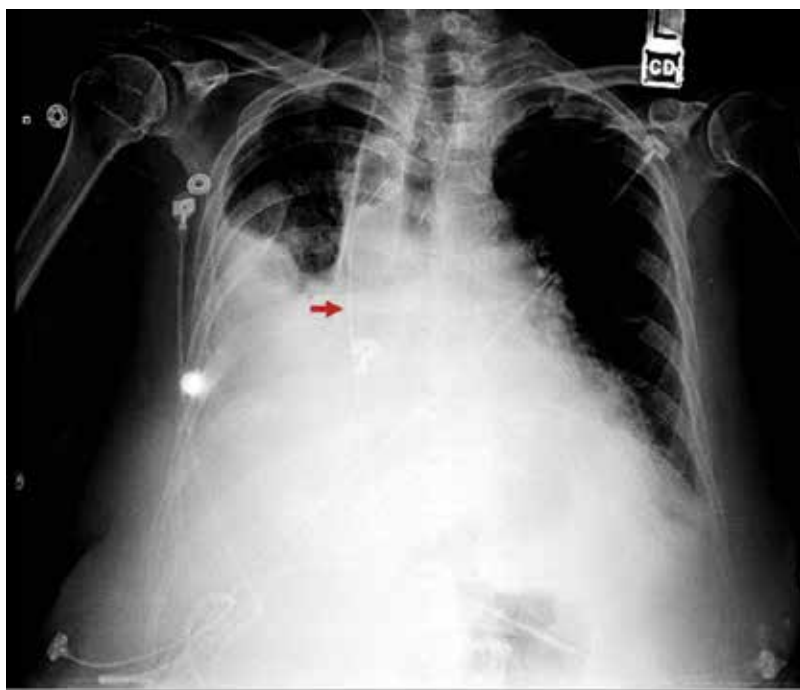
Chest X-ray revealing a retained guide wire (arrow).
